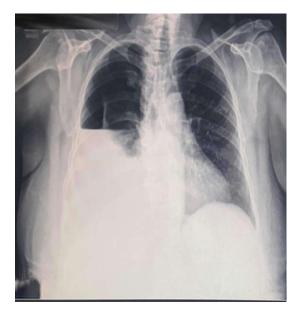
Chest x-ray demonstrating a right hydrothorax in August 2016
